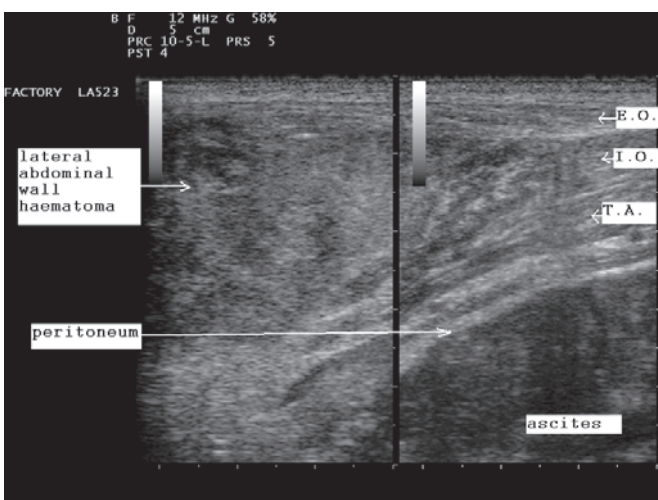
Transverse ultrasound scan of right abdominal wall performed by emergency physician showing a mixed echogenic mass in the lateral abdominal wall. (E.O. external oblique muscle, I.O. internal oblique muscle, T.A. transversus abdominis muscle).
